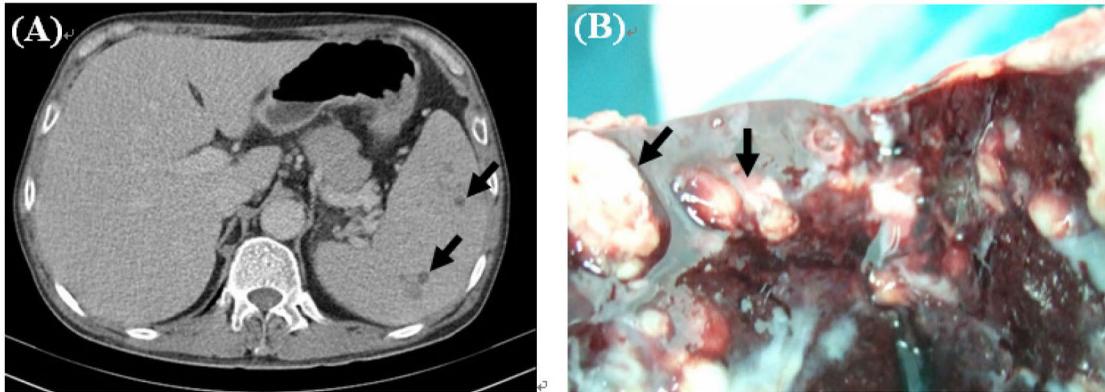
(A) Contrast-enhanced abdominal computed tomography in the venous phase showing multiple low attenuation lesions on the spleen (as arrows). (B) The gross appearance of the resected spleen revealed many abscess formations (as arrows), which were confirmed by pathologic findings.
